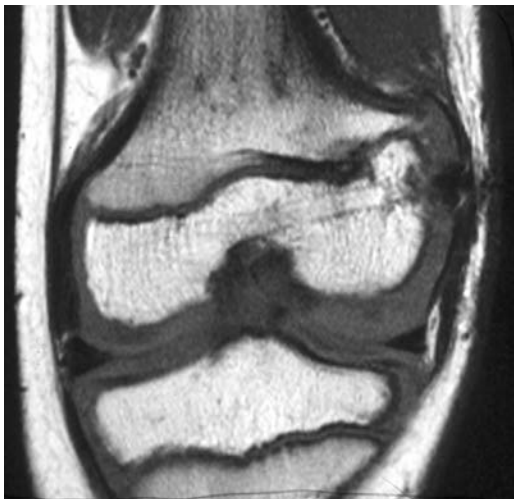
MRI scan of a patient with traumatic lateral distal femoral partial growth arrest. Note Harris arrest line tapering to the site of the arrest.
